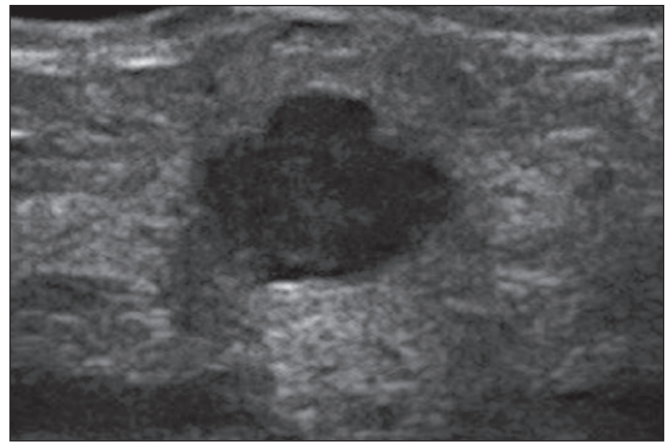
Ultrasound showing a solid, oval, circumscribed, hypoechoic mass with posterior acoustic shadowing, located in the lower inner quadrant of the left breast. Biopsy of the mass led to a diagnosis of B-cell lymphoma.
